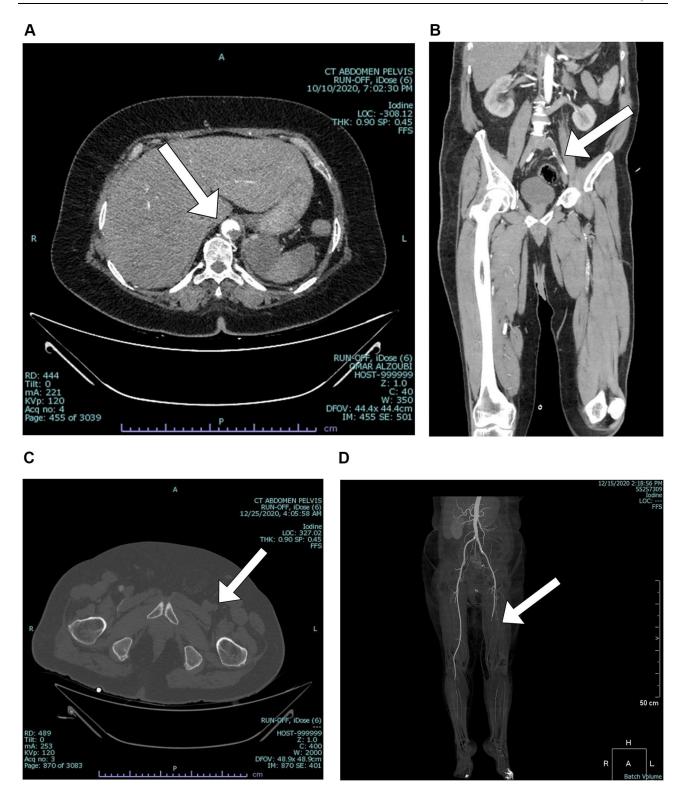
CT-Angiograms show different arterial segments involved in ALLI. (A) Aorta. (B) Aorto-iliac. (C) Common femoral artery. (D) Distal superficial femoral artery.
